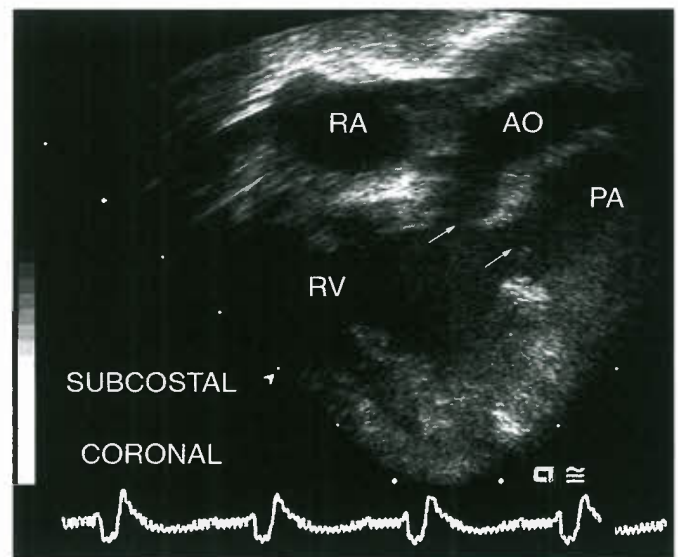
Echocardiogram of DORV with doubly committed VSD. Subcostal coronal view demonstrates VSD in continuity with both great arteries (arrows demonstrate egress to both aorta and pulmonary artery). RV, right ventricle; AO, aorta; PA, pulmonary artery; RA, right atrium.
